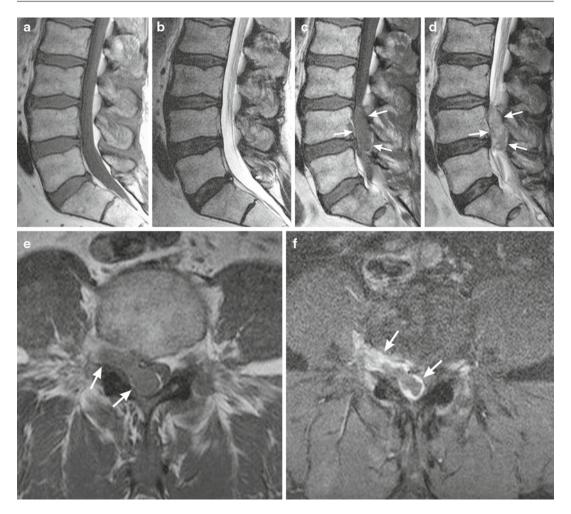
Images of cauda equina compression due to a massive disk extrusion. A 55-year-old man presents with progressive back pain over 6 weeks. T1 (a)-weighted and T2 (b)-weighted sagittal MRI images early in his course show only mild disk degeneration with a widely patent central canal. An MRI, 6 weeks later when bilateral lower limb weakness and perineal numbness began, shows a
